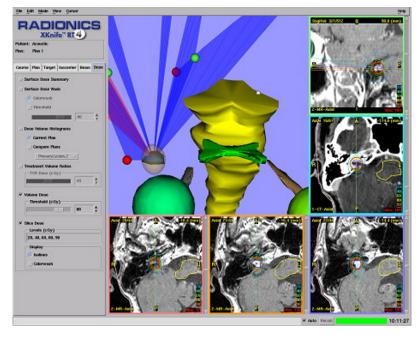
This computerized treatment plan reveals MRI defining the target (encircled in red) and the area of concern to be isolated, the brainstem encircled by an oblong shape. The mock treatment plan shows the eyes and the brainstem, which are isolated from the target. The radiation beams are shown converging on the target, in this case an intracanalicular AN.
